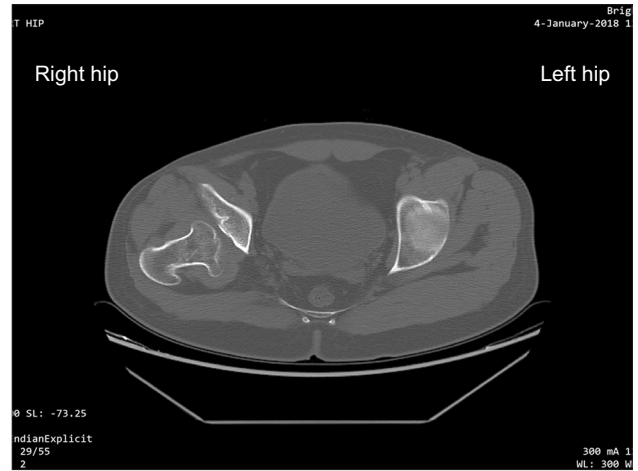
Preoperative computed tomography scan transverse cut at the level of the superior lip of the acetabulum. The affected side (right) shows the hip dislocated and proximally migrated.
